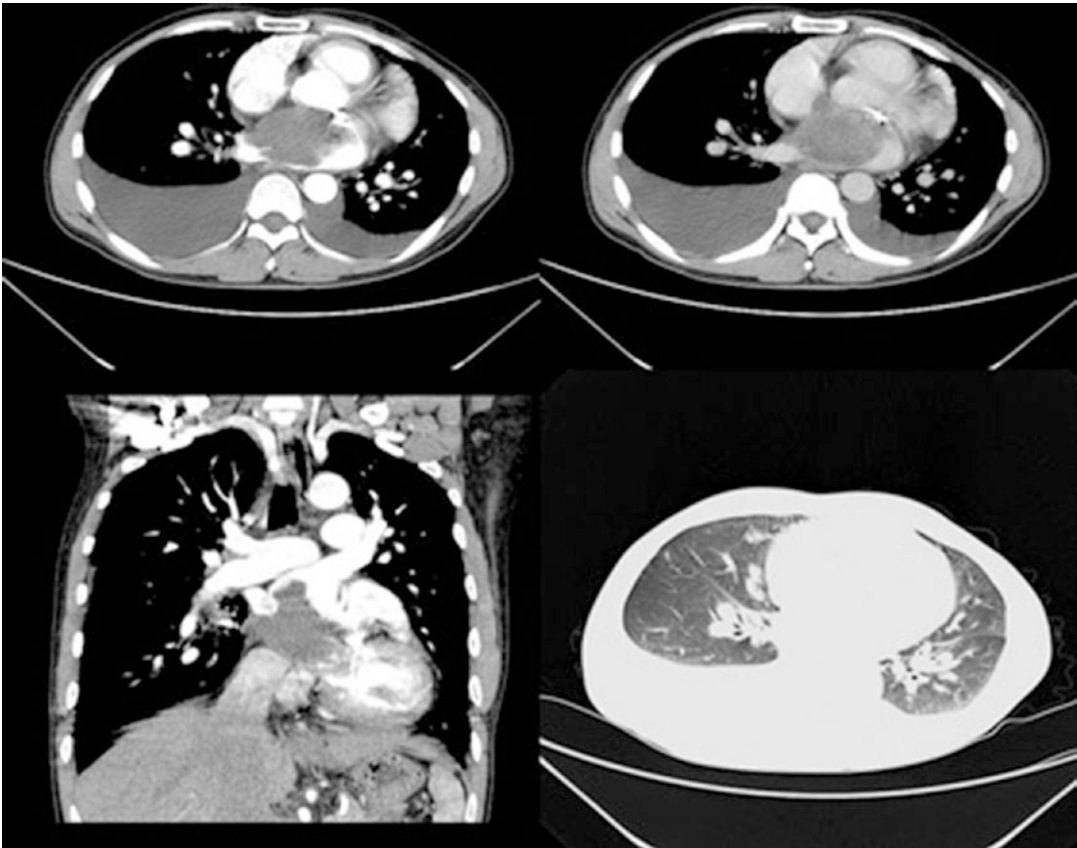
A 42-year-old man who presented with dyspnea and palpitation of 1 month's duration. Contrast-enhanced computed tomography revealed a lobular filling defect in the left atrium
